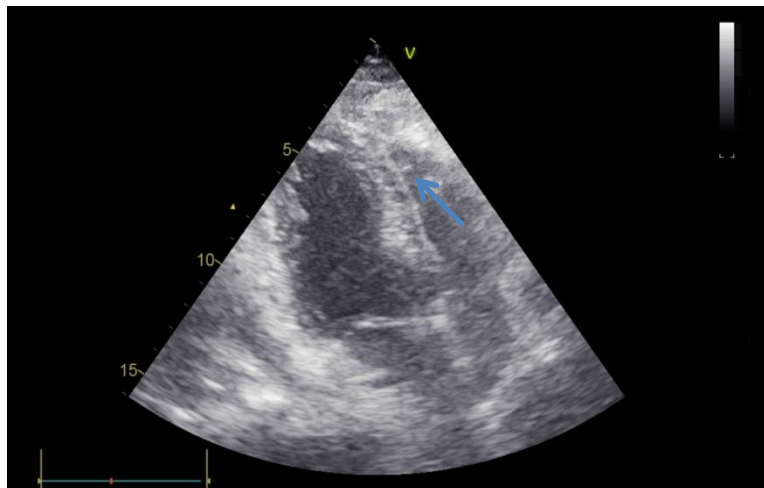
echocardiographic image showing an intracavitary thrombus in the right ventricle
